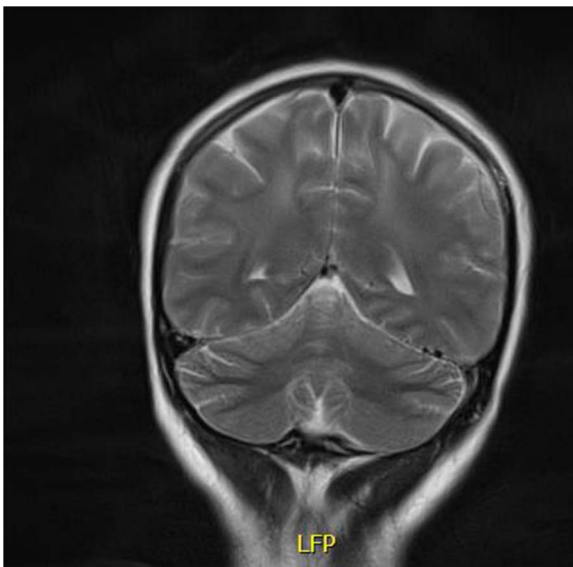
Coronal T2 Flair on magnetic resonance imaging (MRI) of brain.
